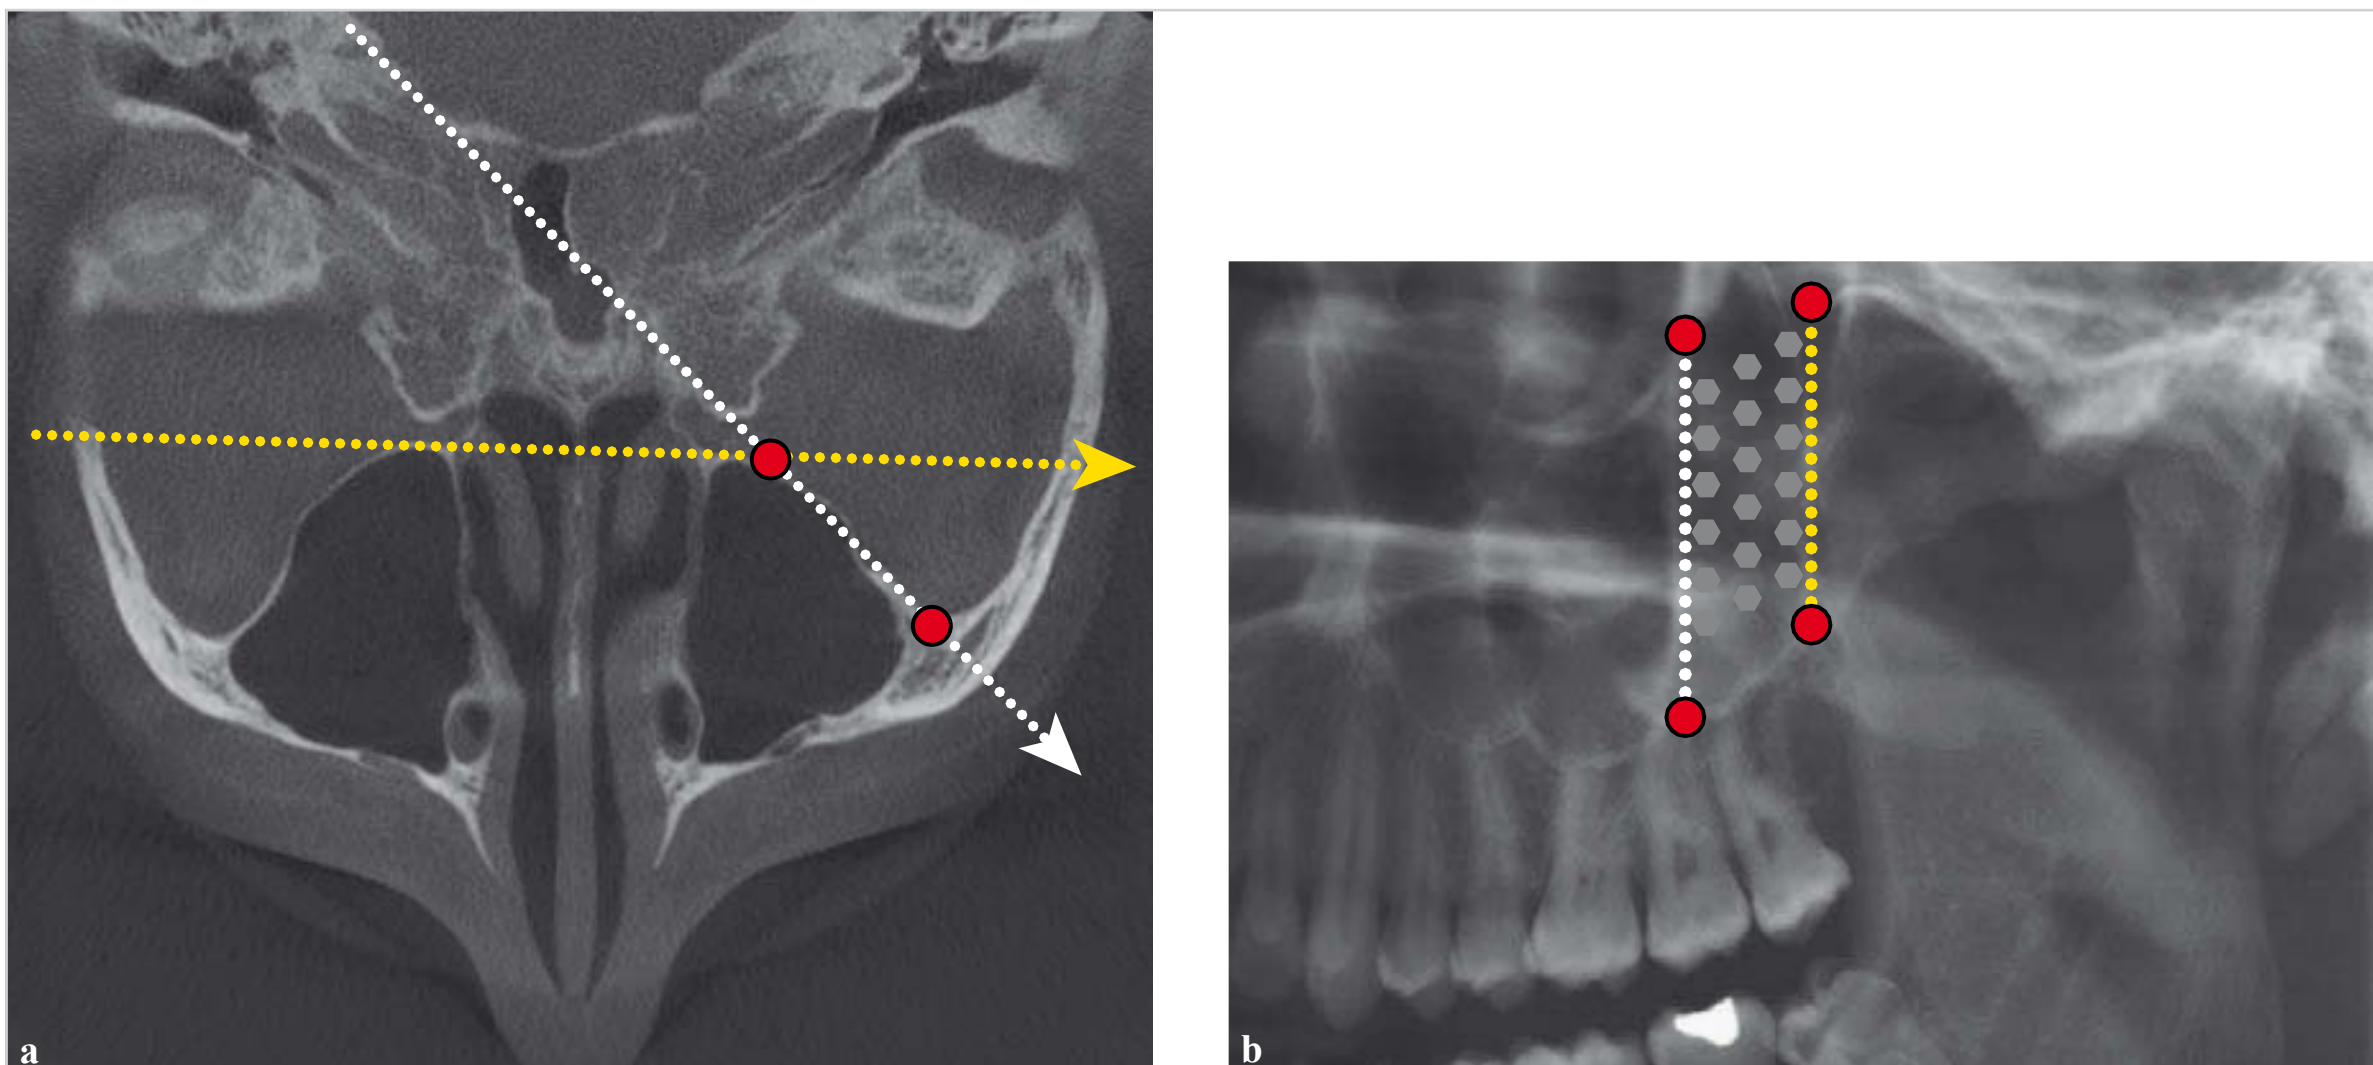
Visualization of the lateral walls of the maxillary sinuses by panoramic radiography.
